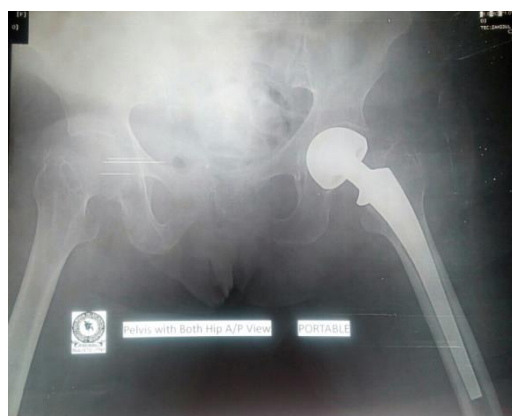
postoperative anteroposterior X-RAY view of the patient managed by primary cemented bipolar hemiarthroplasty
